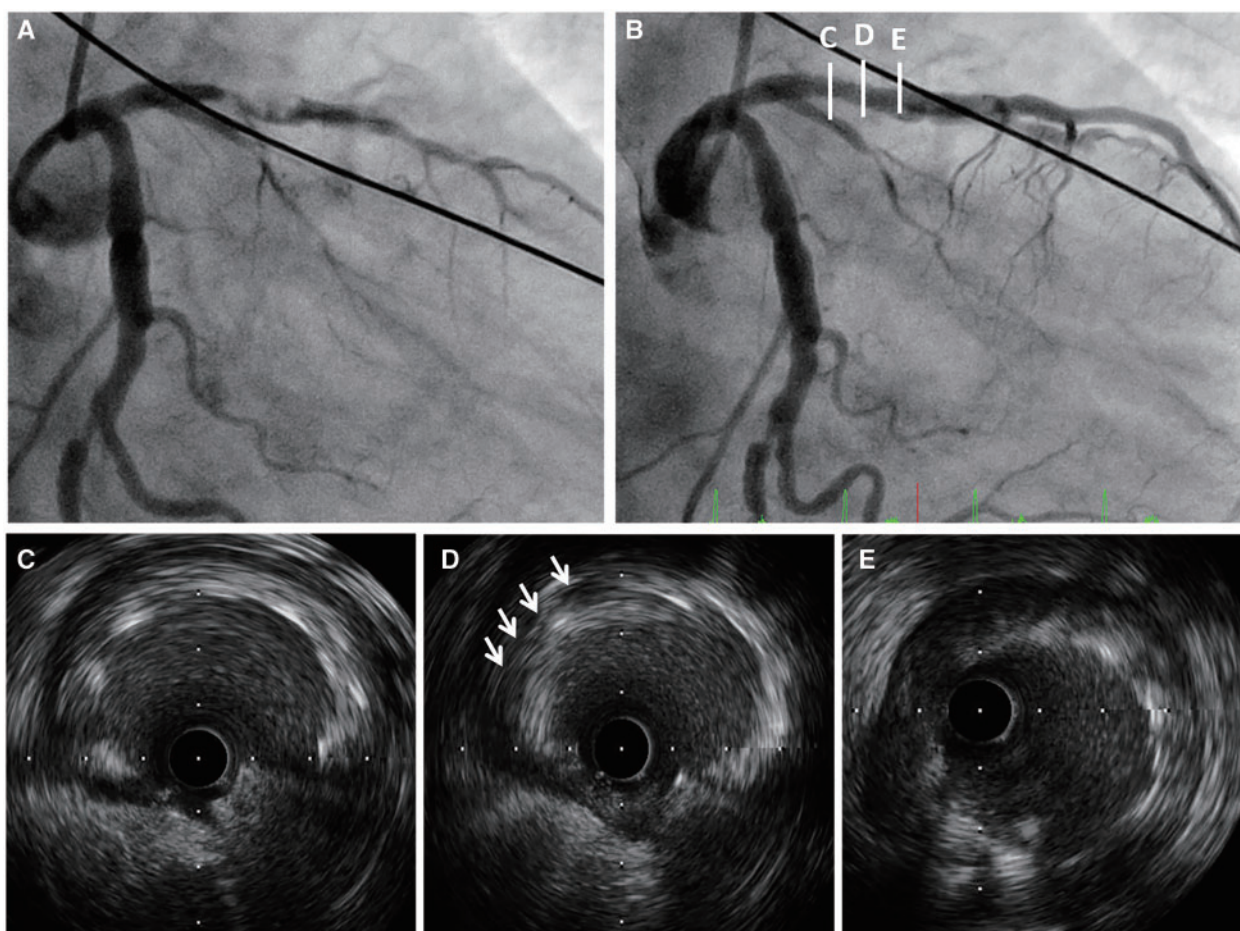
Coronary angiography and intravascular ultrasonography images before (A) and after (B–E) implantation of an everolimus-eluting platinum chromium stent. Intravascular ultrasonography demonstrates good apposition and stent expansion to the vessel wall. Only slight thrombi persist inside the stent (D, white arrows).
